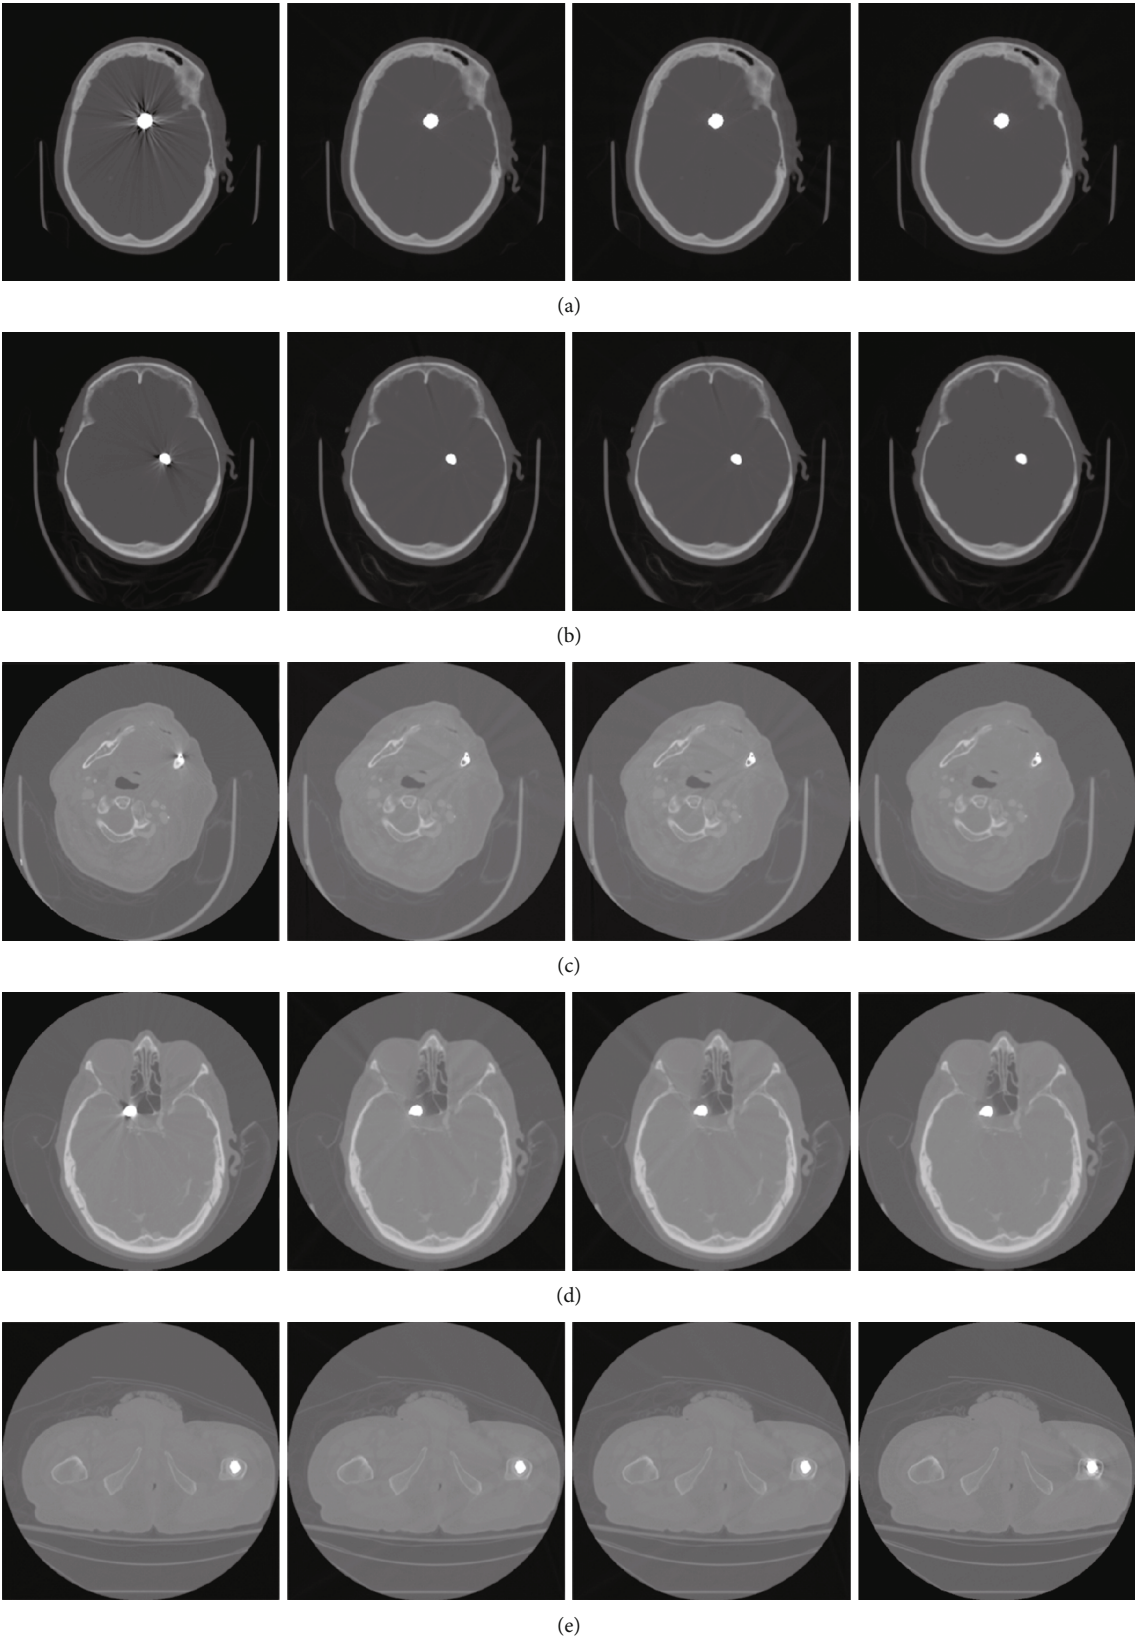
Streak metal artifact reduction in clinical cases with a metal object. Five sets of original and corrected results corresponding to (a–e). Each set successively contains the original, L-MAR, P-MAR, and F-MAR images. (a, b) Two patients with two deep brain stimulators. The patient with (c) has a metallic dental filling, while the head CT images with a cerebral artery aneurysm are shown in (d). (e) A patient with unilateral hip prostheses ($C = 500 \text{ HU}/W = 1500 \text{ HU}$).
